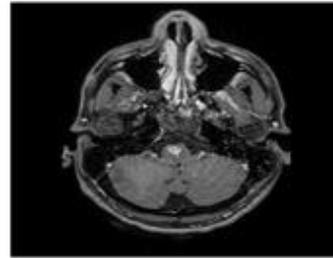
Behcet disease in the Pons. Gadolinium enhanced 3 T T1 weighted MRI of the brain demonstrating enhancing nodular lesion in the Pons in a patient with history of mouth ulcers.
